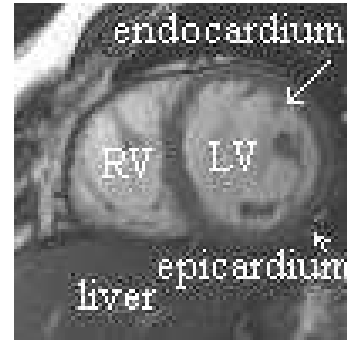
Effects of intensity inhomogeneity in MR images. Images based on [36].
